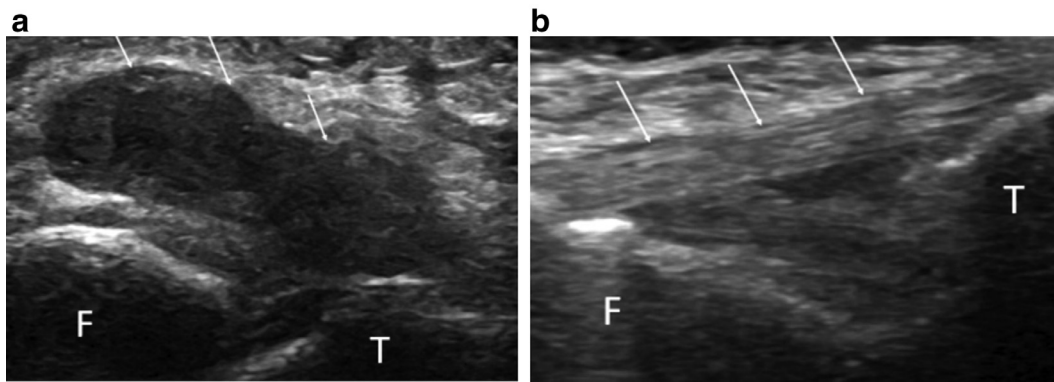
Long-axis sonographic image of the lateral right ankle of 17-year-old boy following a soccer injury (a). A full-thickness tear of the anterior talofibular ligament presents as a complex hypoechoic fluid collection (arrows) in the expected location of the normal ligament. Normal ATFL (arrows) for comparison in a 9-year-old boy (b). F, fibula; T, talus.
